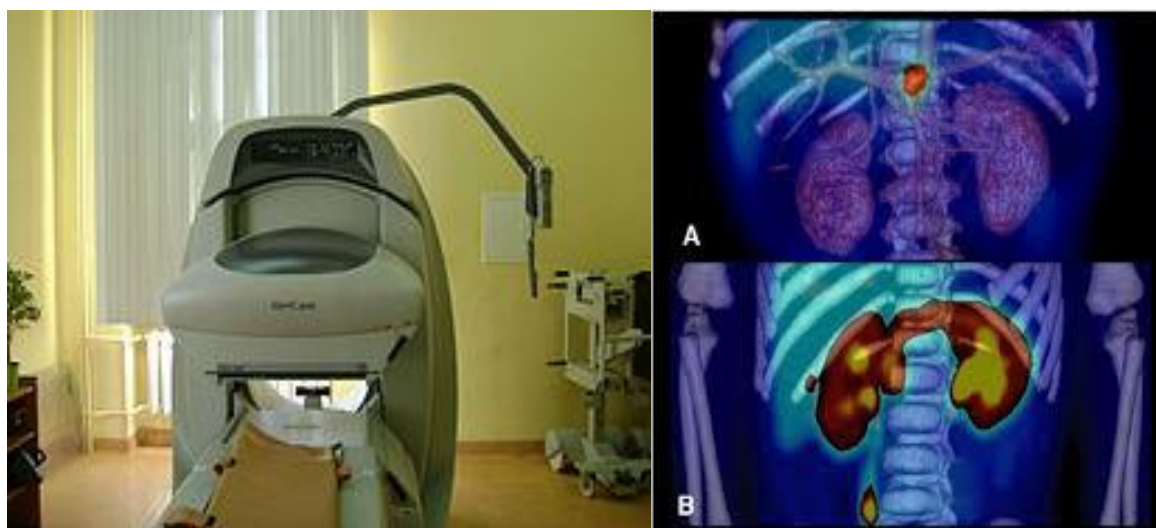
X-ray study to check gastric retention of tablet
